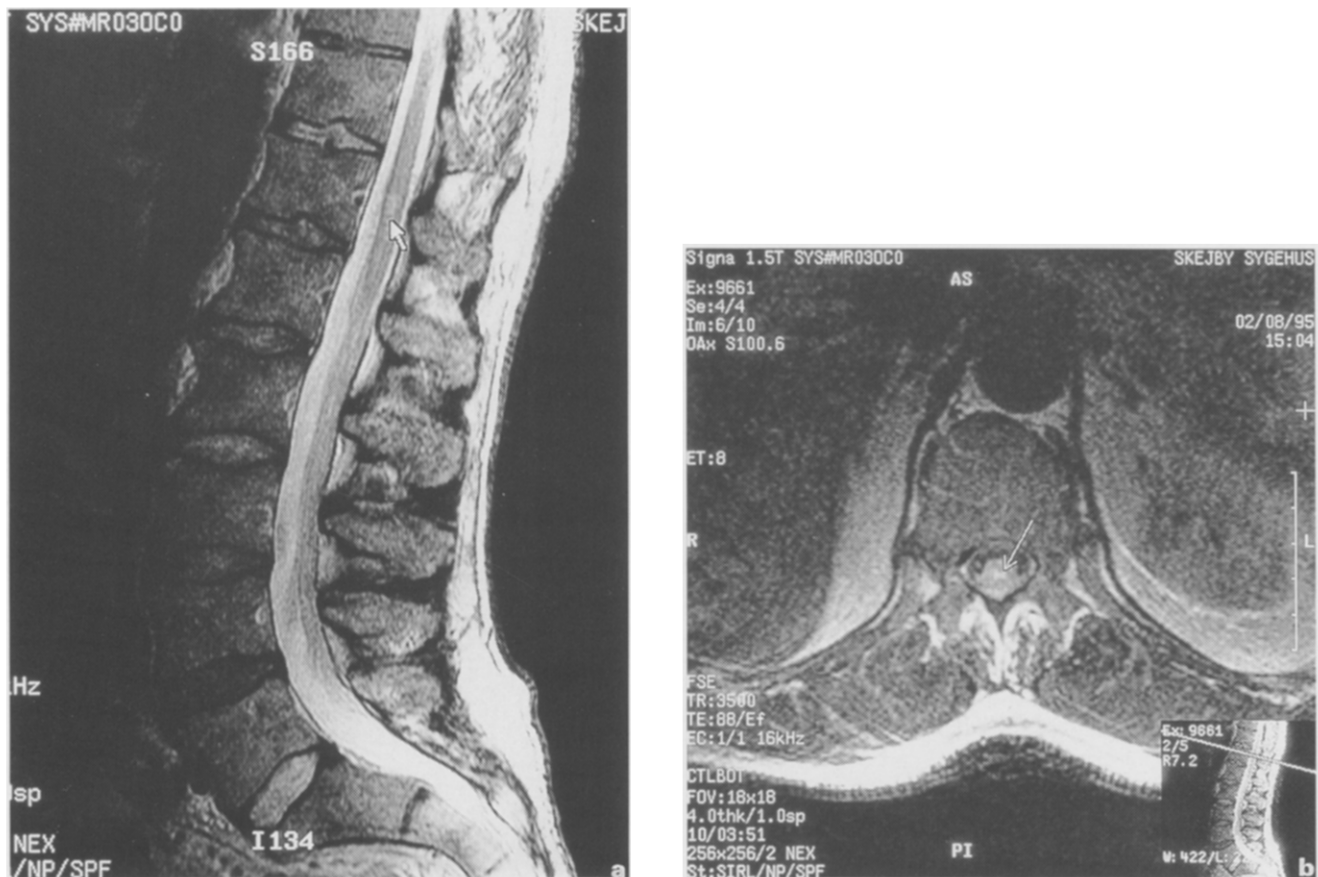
Case 2. Focal area of signal hyperintensity on T2-weighted images (a) sagittal projection, (b) axial projection
